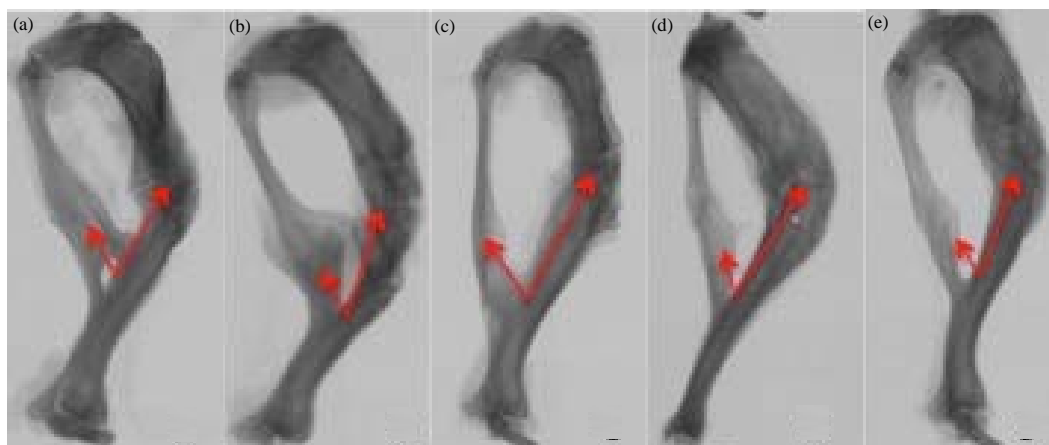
(a-e): X-ray images of fractured tibiae after 8 weeks of treatment. Arrow indicates stabilization of fibula and healed fracture line of the tibiae, respectively
